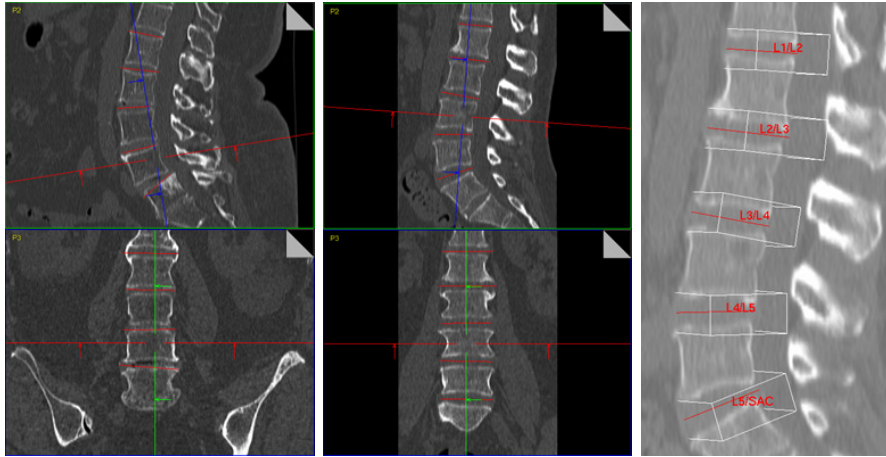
Detection results for CT scans of the lumbar spine.
